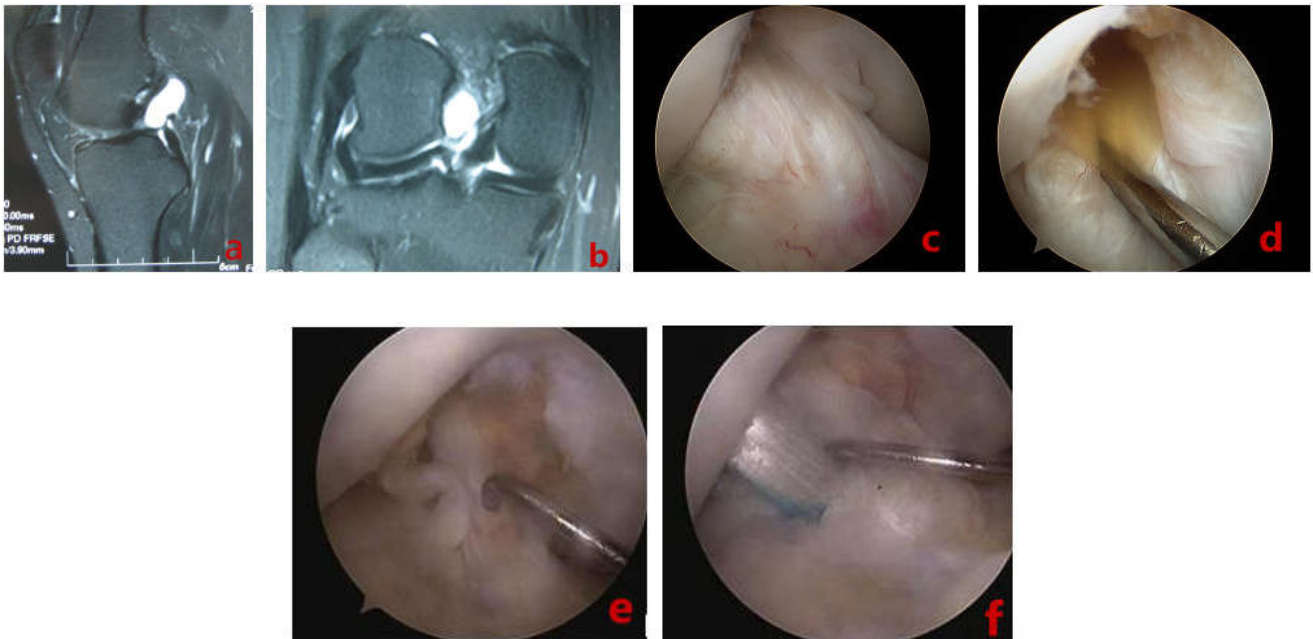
Figure a,b—magnetic resonance imaging shows area of high signal intensity, represents a ganglion cyst
